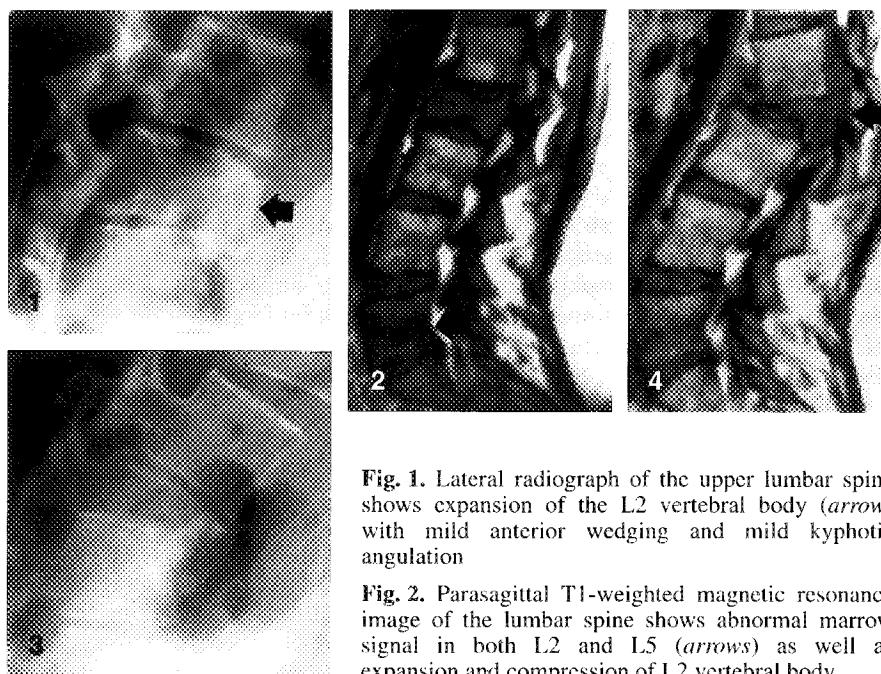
Lateral radiograph of the upper lumbar spine shows expansion of the L2 vertebral body (arrow) with mild anterior wedging and mild kyphotic angulation
